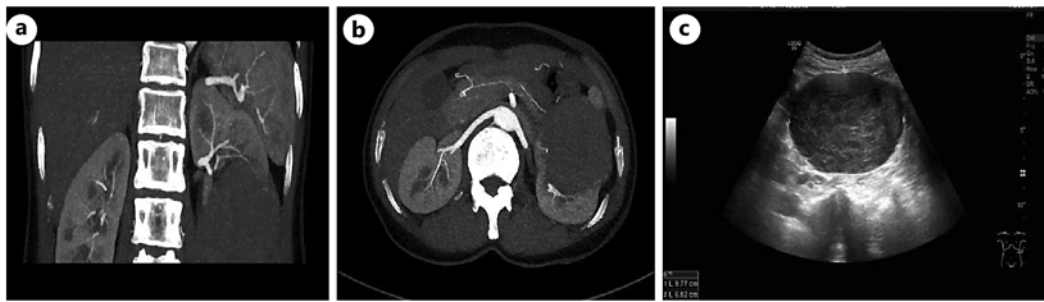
CT and ultrasound imaging of the kidney reveal a mass lesion in the left kidney. a Coronal CT angiography unveils a low-density round lesion in the left kidney. b Axial CT angiography displays a low-density lesion with smooth margins in the left kidney. c Ultrasound imaging demonstrates a hypoechoic mass lesion in the left kidney.
